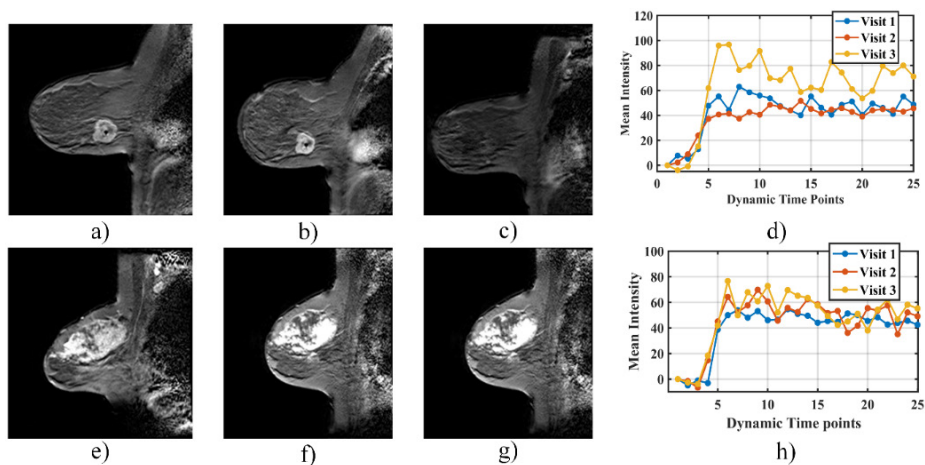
(a–h) DCE-MR images of two PCR patients represented in each row at Visit 1 (column 1), Visit 2 (column 2), Visit 3 (column 3), and corresponding time points versus mean intensity curves (column 4)
